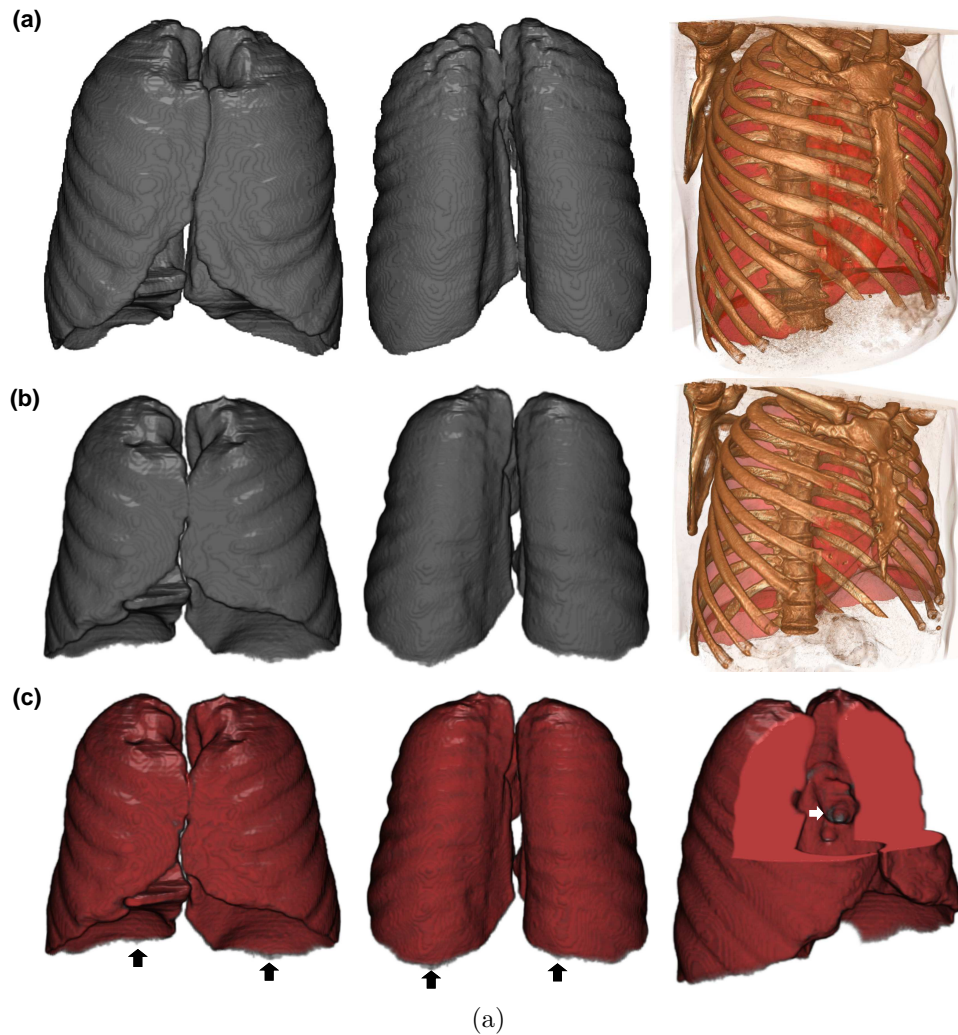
Result of the Lungs CT image registration: (a) Manual Lung segmentation in the atlas' CT-image (at each column, from left to right: front view, back view, and 3D ribcage CT reconstruction surrounding the Lung's manual segmentation), (b) Manual Lung's segmentation in a subject's CT-image (at each column, from left to right: front view, back view, and 3D ribcage CT reconstruction surrounding the Lung manual segmentation), (c) Atlas-driven subject-specific Lungs, in grey, superimposed on the manual segmentation, in red (at each column, from left to right: front view, back view, and a cut-out to the region having less accuracy).
